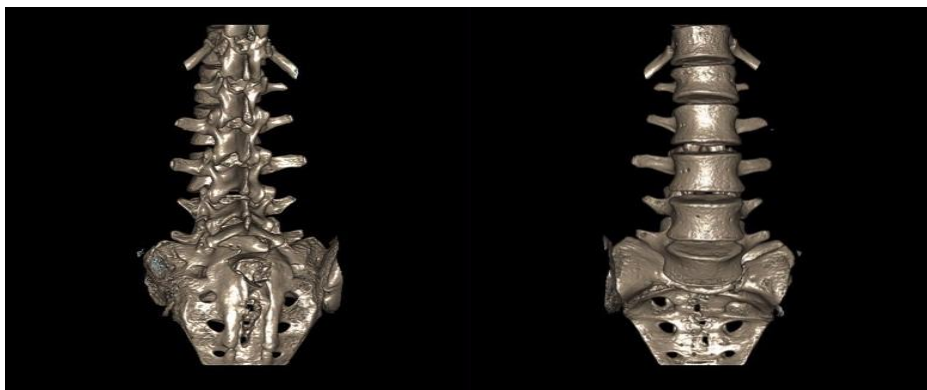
Three dimensional CT imaging displays lamina fractures (a) of S1-S2 level with no marked dissociations (b).
